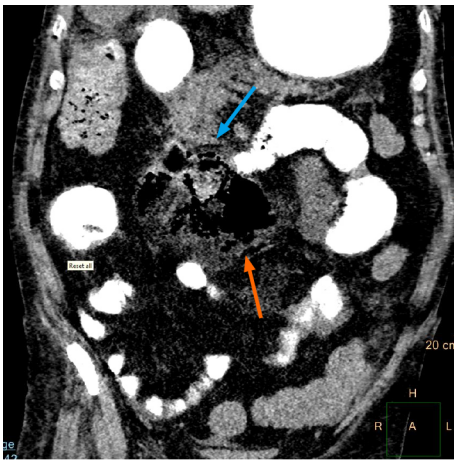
Bowel perforation detected on a computed tomography scan of the abdomen and pelvis performed for evaluation of severe abdominal pain and abdominal distension in a critical patient with coronavirus disease 2019. Positive oral contrast is seen to opacify small and large bowel loops. There is evidence of jejunal perforation with a localized air collection in the mesentery (orange arrow) at the site and adjacent inflammation (blue arrow). The proximal jejunal loops appear dilated. The patient underwent emergency laparotomy with resection and anastomosis.
